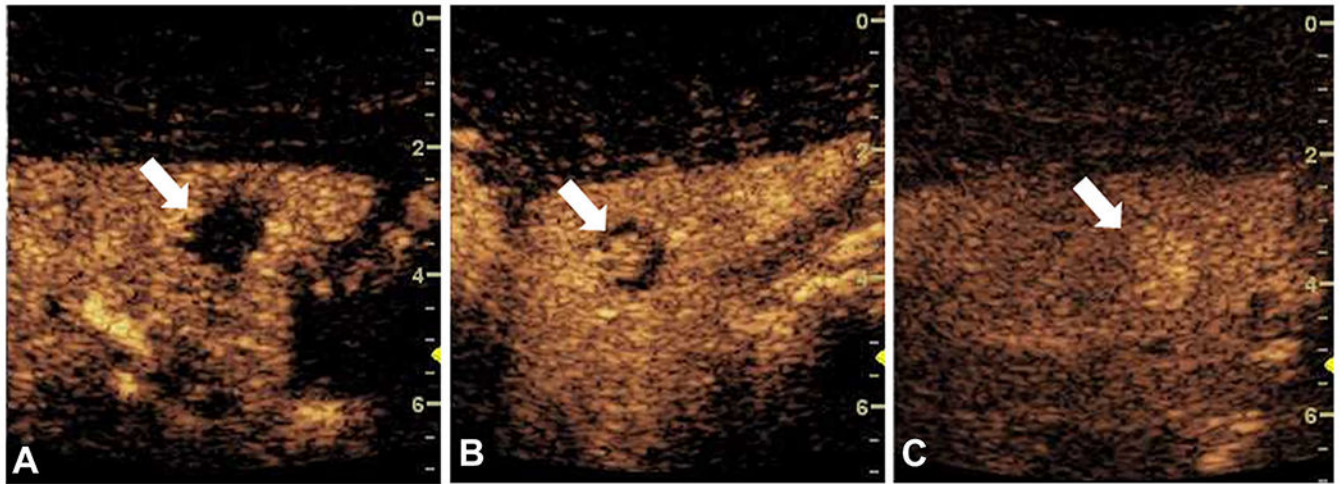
Contrast-enhanced ultrasound of an indeterminate liver lesion (arrow) showing peripheral discontinuous globular enhancement (from the left of the image and extending towards the center of the lesion) with progressive central filling and persistent hyper-enhancement, consistent with hemangioma. (A) 16 s after bolus injection. (B) 39 s after bolus injection. (C) 167 s after bolus injection.
